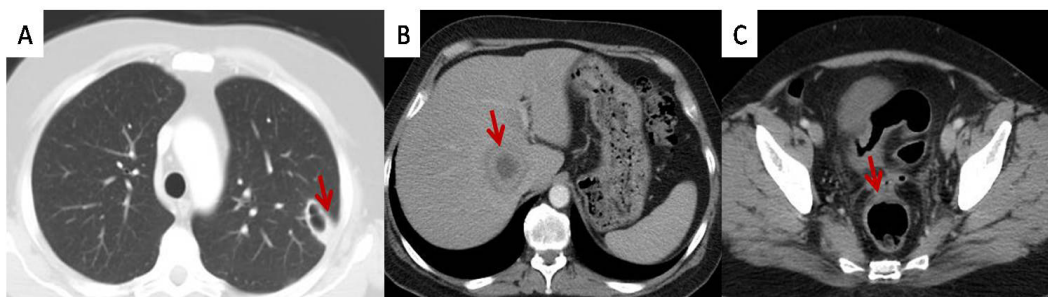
On day 16 of treatment; A: Thorax CT scan: Left upper lobe lung abscess was getting smaller after treatment. B: Upper Abdominal CT scan: The liver abscess had shrunk and there were fibrous like structure. C: Lower Abdominal CT scan: Substantially shrunke.
